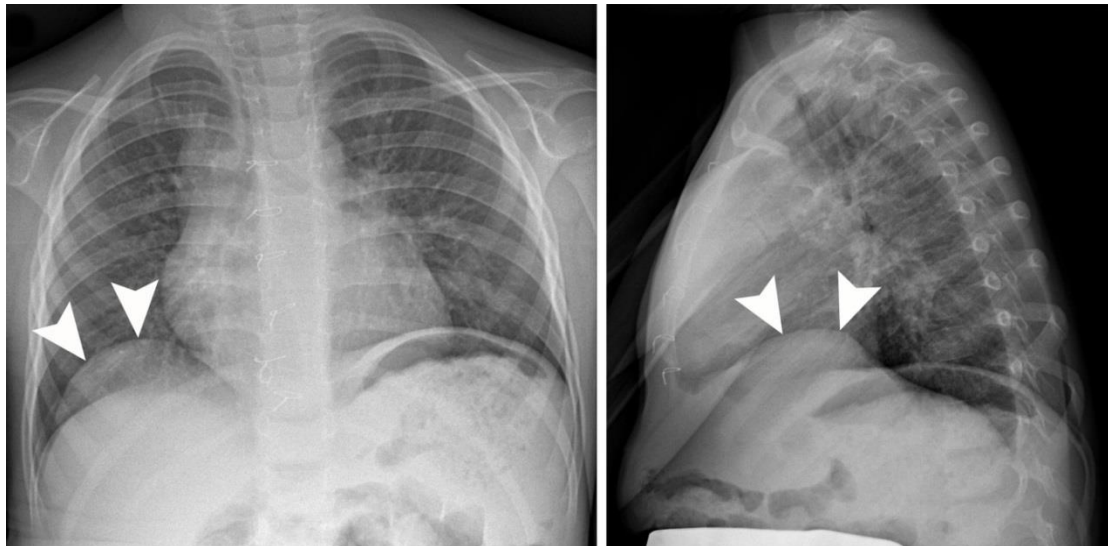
Shows the diaphragm eventration observed on X-ray in the sibling affected with a total anomalous pulmonary venous return (TAPVR) who was shown to also carry the p.Arg112\* *ZFPM2* mutation. The left image shows the frontal view and the right image shows the view from the patients left side. The anterior right sided diaphragm eventration is highlighted with the white arrow heads.
